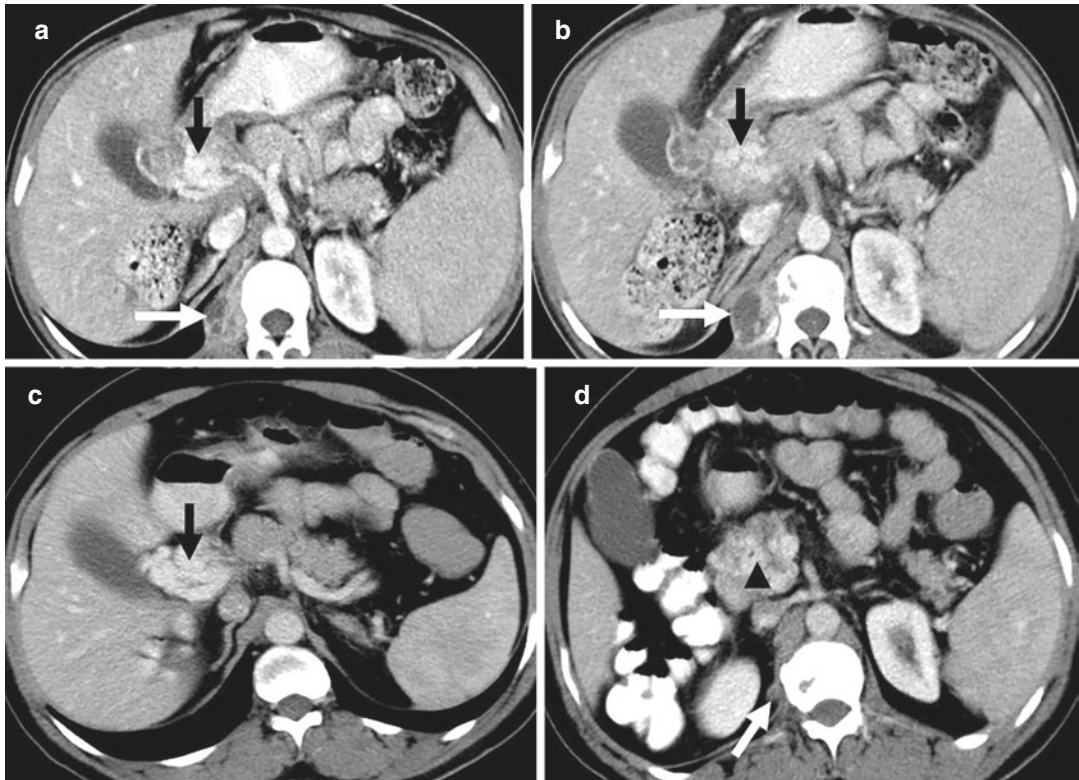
Periportal tuberculous lymphadenitis causing portal cavernoma in a 46-year-old man with spinal tuberculosis. (a and b) Axial contrast-enhanced CT images show a right paraspinous abscess (white arrows) and periportal nodal mass encasing a portal cavernoma (black arrow). (c
